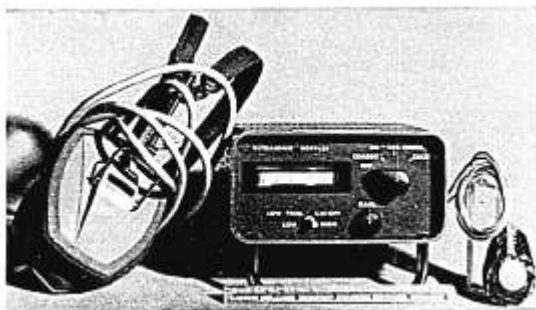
Operational Doppler unit, with standard headphones on the left and Doppler transducer containing sending and receiving zinc titanate-zirconate crystals on right.
